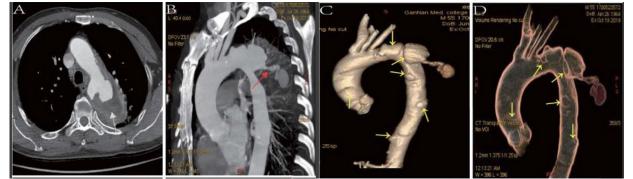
(A) Chest computed tomography angiography reveal a pseudoaneurysm arising from the proximal of descending thoracic aorta, with peri-aneurysmal hematoma (white arrow). (B) The pseudo-aneurysm cause extrinsic compression of the left upper lung and aortobronchial fistula formation following the rupture of thoracic aortic pseudoaneurysm (red arrow). (C) Three-dimensional computed tomography reconstruction(3-DCT) shows thoracic aortic pseudoaneurysm and multiple penetrating aortic ulcers. (D) Transparent aorta manifestation of the 3-DCT.
